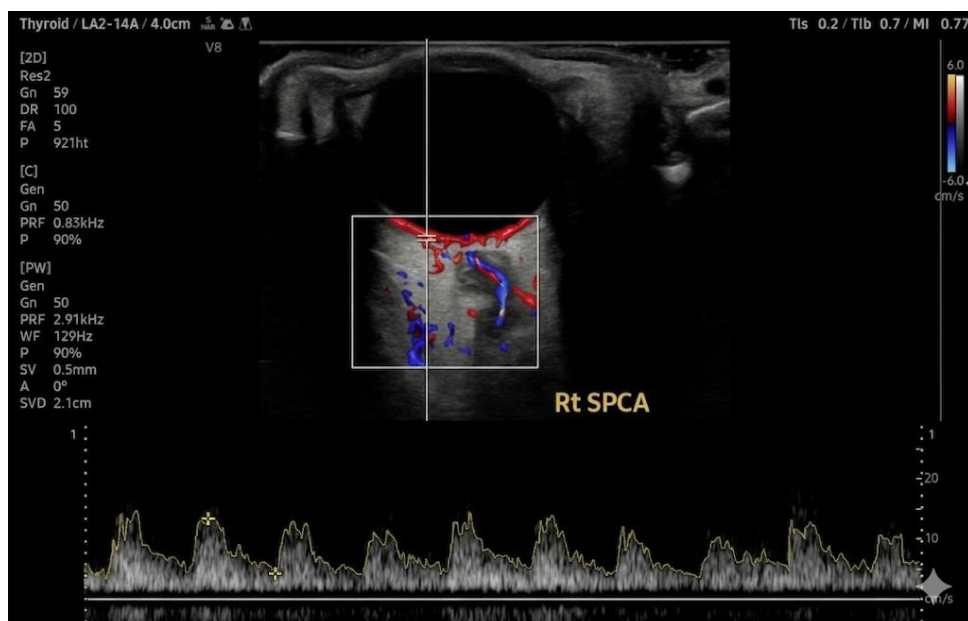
Colour Doppler of Normal Short Posterior Ciliary Artery
